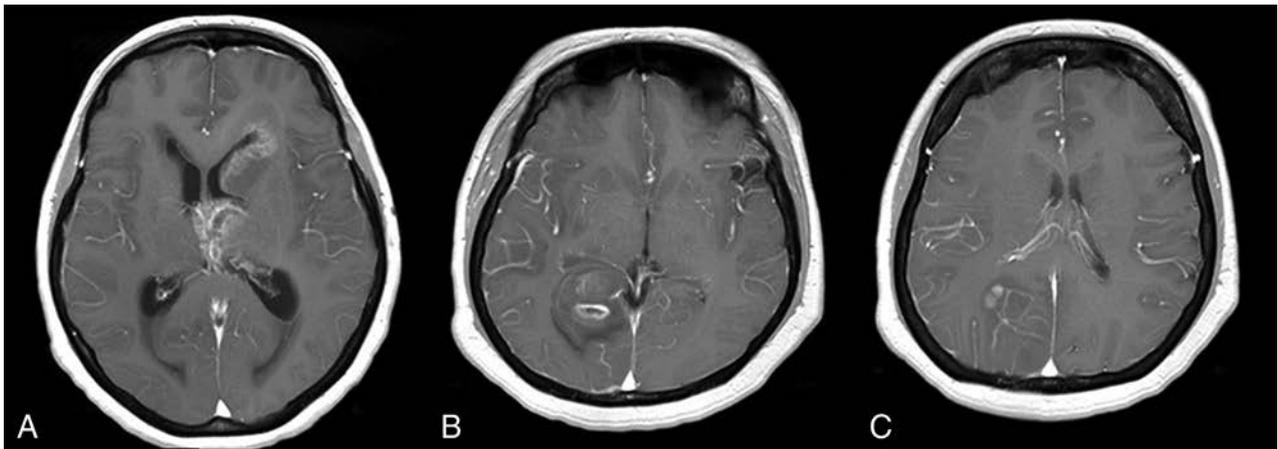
A, Axial contrast-enhanced T1-weighted image of a 51-year-old woman with a grade IV glioma. All 3 radiologists incorrectly classified the tumor as PCNSL, whereas the SVM classified it correctly in 92% of the trials. B and C, Axial contrast-enhanced T1WI of a 47-year-old woman with a grade IV glioma. All 3 radiologists incorrectly classified the tumor as PCNSL, whereas the SVM classifier provided the right diagnosis in 88% of the trials.
